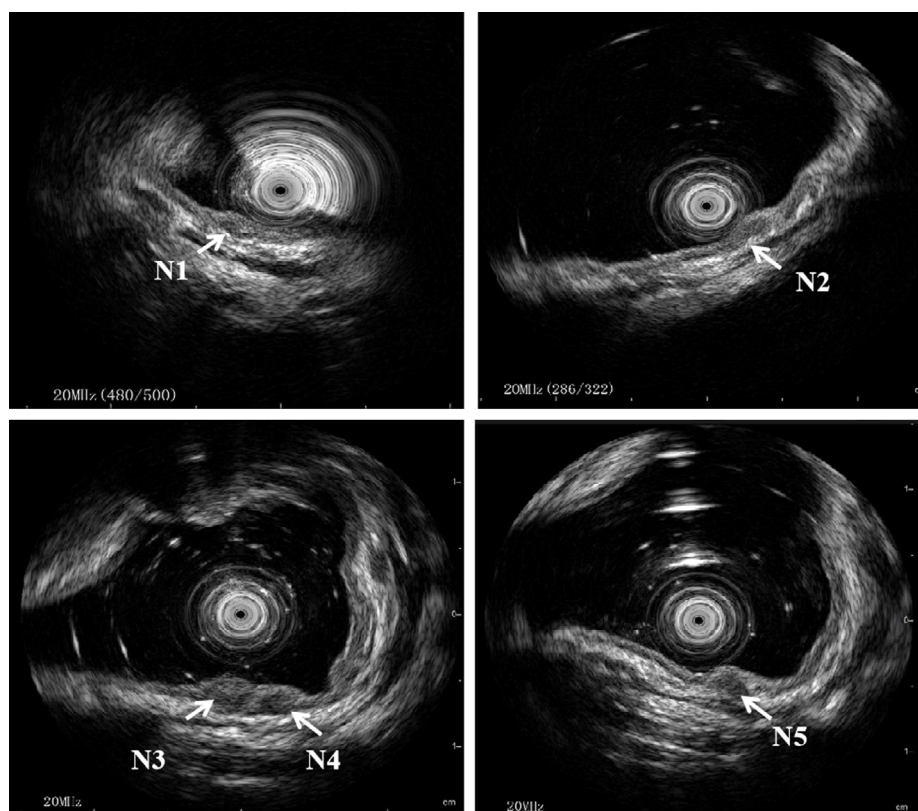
Ultrasonography colonoscopy of the patient
